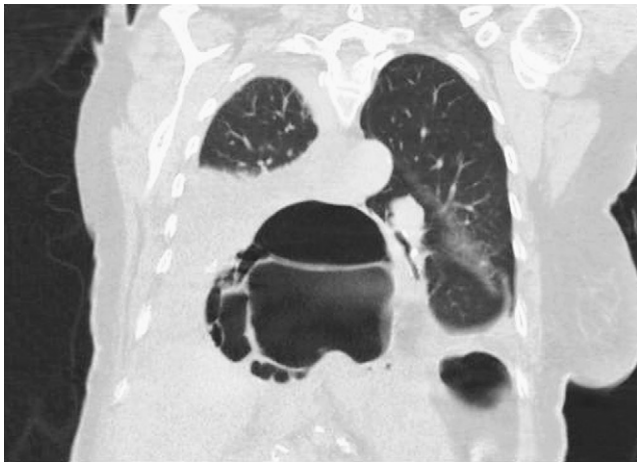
CT scan of the thorax, coronal views, depicting an air fluid level and free air in the posterior mediastinum.
